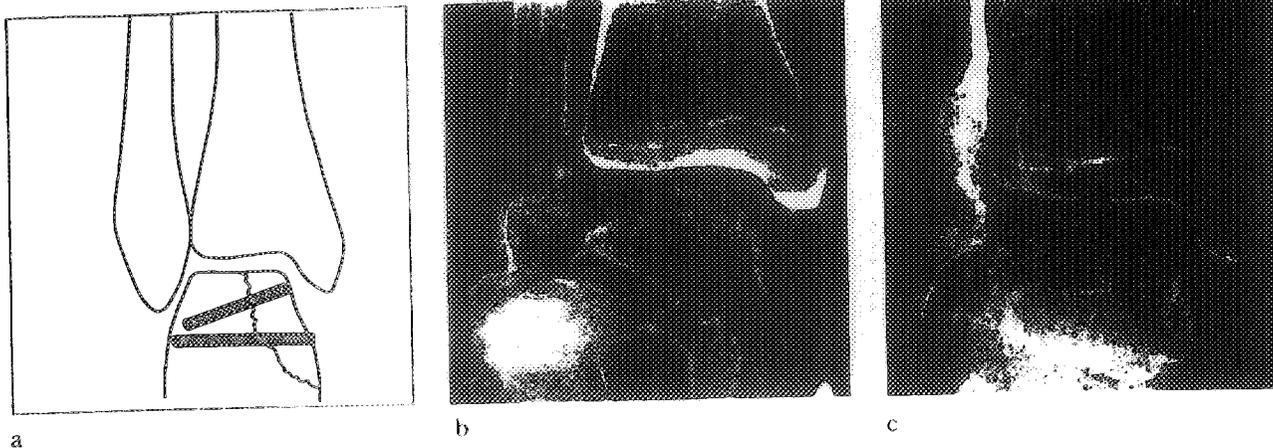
Fixation of fracture of the talus (a). Radiograph of a vertical fracture of the talus seen on admission (b) and as healed one year after fixation with two 3.2 by 50 mm BIOFIX®-rods (c).
